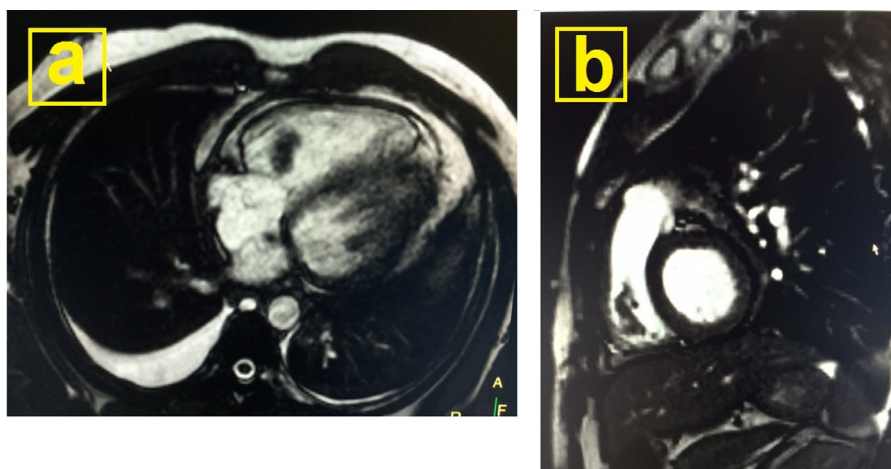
a) Cardiac MRI T2 weighted image showed a 20 × 10 mm mass in RV which was iso-intense to the myocardium, with possible attachment to the chordae or the RV free wall. b) contrast MRI showed no contrast enhancement of the mass or the adjacent myocardial wall.
